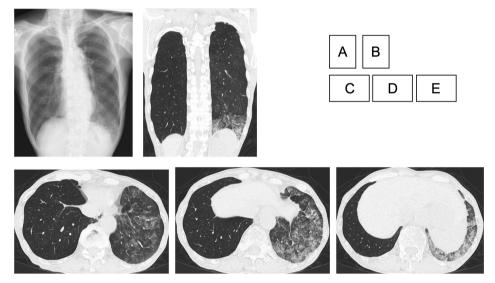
Chest X-ray and CT findings. (A) The chest radiograph and (B–E) chest CT scans. CT images show patchy consolidations and ground-glass opacities with septal wall thickening, forming a 'crazy paving' pattern in the left lower lobe. CT = computed tomography.
